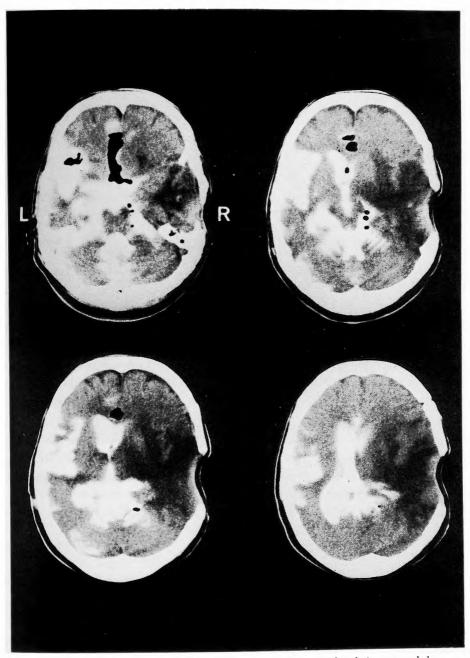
Metrizamide CT after VP shunt. All ventricles, the basal cisterns, and the left sylvian fissure were communicating with each other. The right sylvian fissure and the subarachnoid space over bilateral convexities were not filled with metrizamide. The size of ventricles decreased.
